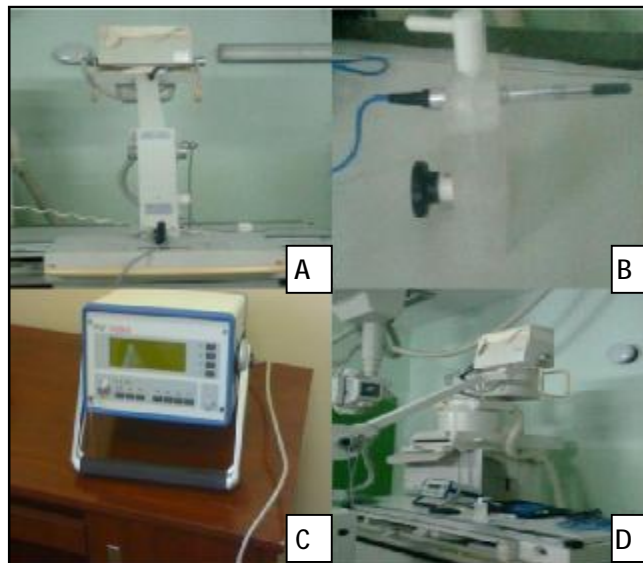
A- X-ray machine, B- Farmer ionization chamber, C- PTW UNIDOS electrometer and D- All of the previous equipments.
